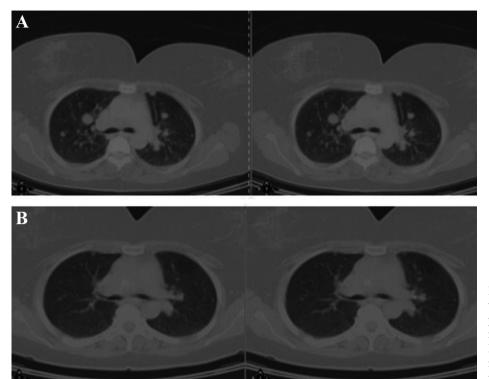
A: PET/CT scan at the time of presentation shows multiple nodules in both lungs, which do not show 18F-FDG uptake. B: PET/CT scan taken after about ten months from treatment showed that nodules disappeared.
